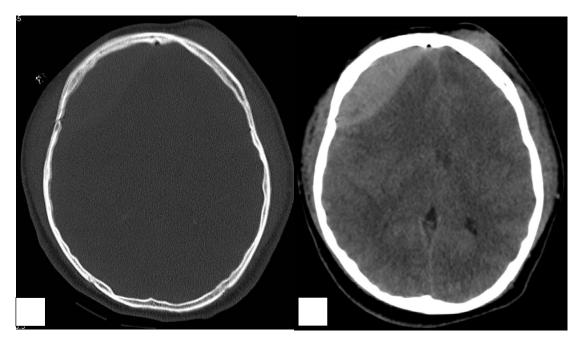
Axial plain CT brain of a 22-year old patient showing (a) bone window; linear fracture at the right parietal and (b) subdural window; extradural haemorrhage at the right frontal.
